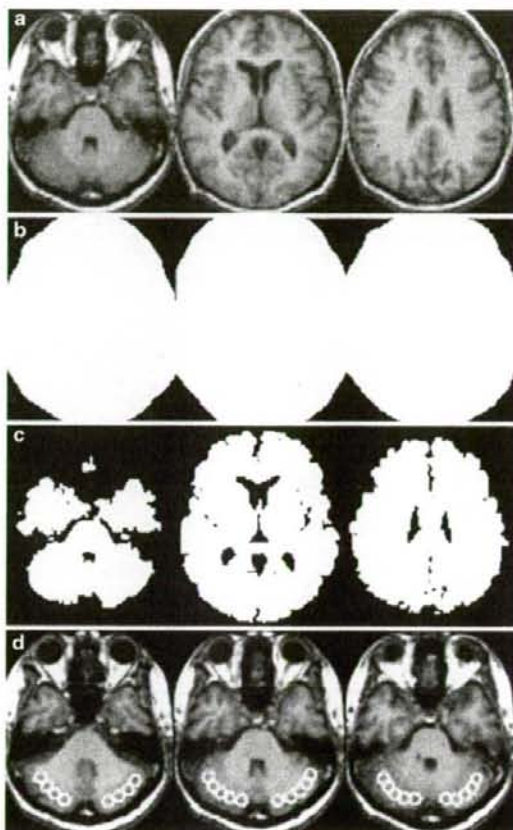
An example of the brain regions investigated. a The space normalized 3D-magnetic resonance imaging (MRI) image of a subject. b Statistical parametric mapping global brain (SPMgb) computed from the 2-[^{18}F]fluoro-2-deoxy-D-glucose positron emission tomography (FDG-PET) image of the subject in the fasting condition in default in SPM program (smoothed using a Gaussian filter with a 16-mm full width at half-maximum). SPMgb in the mild hyperglycemic condition was nearly equal to that in the fasting condition (not shown). c MRIgw consisting of the gray and white matter regions computed from the 3D-MRI image of the subject using SPM segmentation function. d Cerebellar cortex [Cbll, region of interest (ROI) on cerebellar cortex] consisting of 48 circles 10 mm in diameter on five continuous slices
